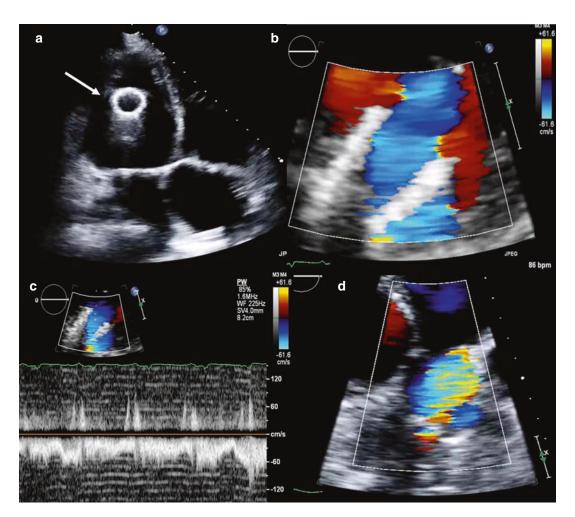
Echocardiographic images from a patient on HeartMate II left ventricular assist device. (a)–(c) Inflow cannula is seen at the left ventricular apex with laminar
